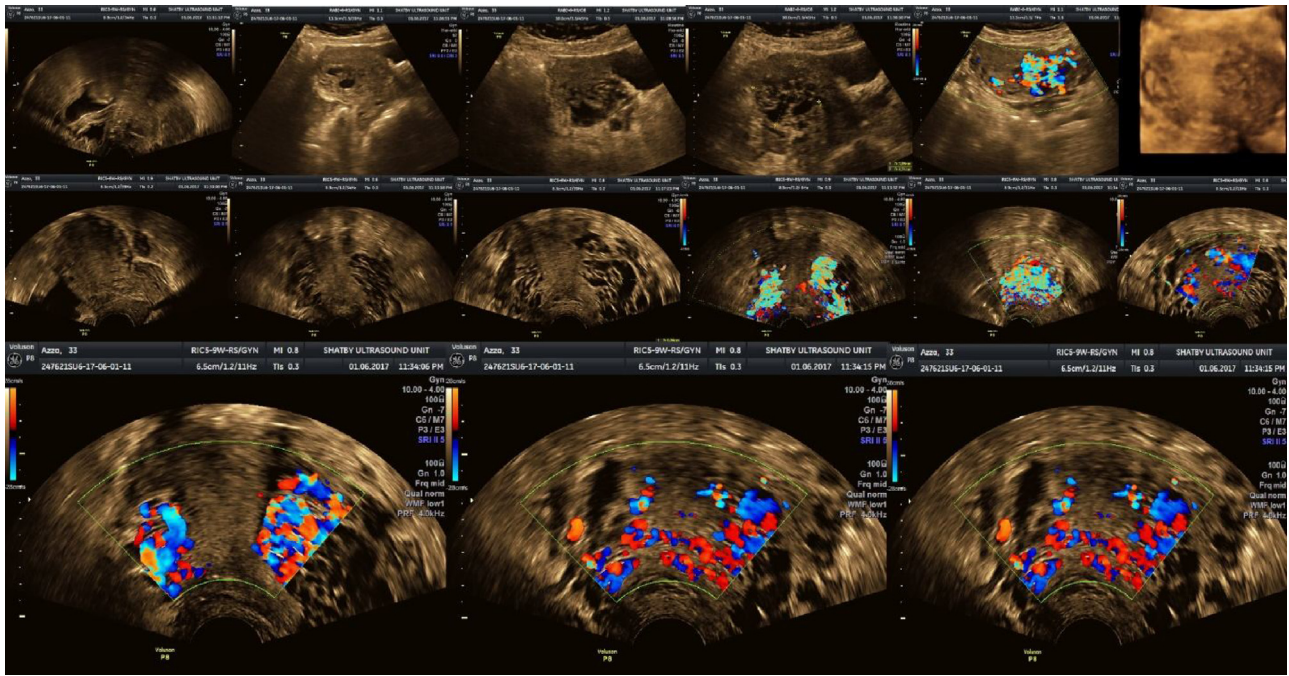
trans abdominal and trans vaginal ultrasound scan revealing dilated anechoic blood vessels involving most of the myometrium with dilated parametrial one. Color Doppler revealed intense and rich vascularity with high signal throughout the myometrium.
